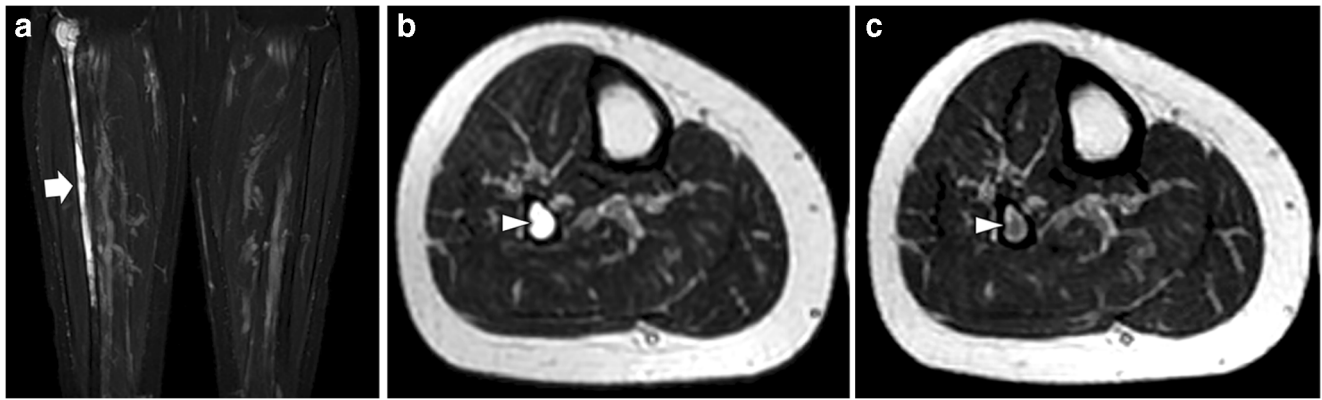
a Coronal fat-suppressed T2-weighted, b transverse T2-weighted and c transverse contrast-enhanced T1-weighted MR images of the right leg. The extensive lesion (arrow) demonstrates homogeneous high signal
